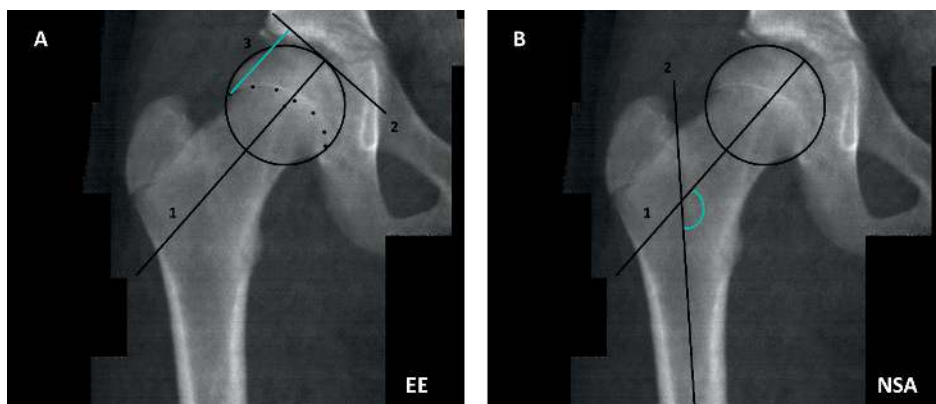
Measurement of lateral epiphyseal extension (EE) and neck shaft angle (NSA) on a dual-energy x-ray absorptiometry (DXA) image of the right hip. (A). The lateral EE is the ratio of the length of line 3 and the length of the femoral head radius. First, a perpendicular line (line 2) is generated from the femoral neck axis (line 1) to tangent the best-fitting circle. Line 3 is generated perpendicularly from line 2 to the lateral endpoint of the femoral head growth plate. (B). The NSA is the angle between line 1, the femoral neck axis, and line 2, the femoral shaft axis.
